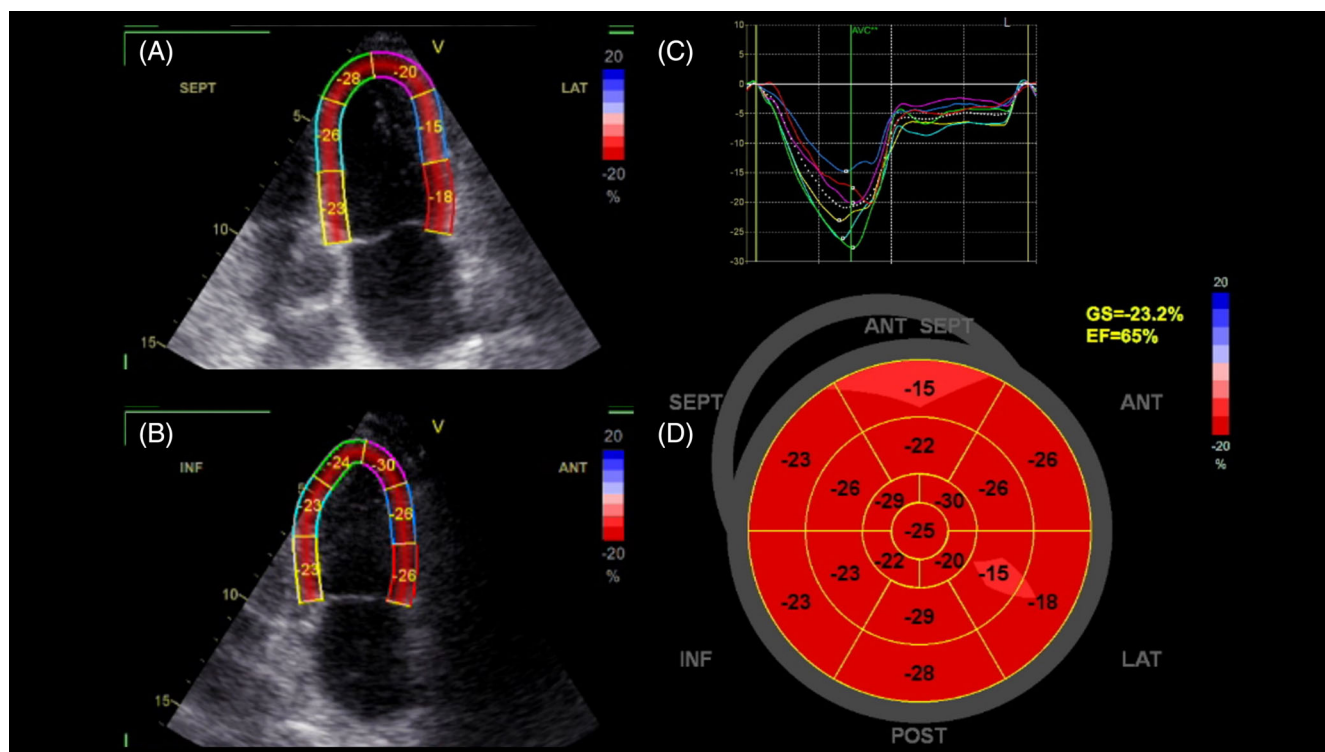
An example of speckle-tracking echocardiography is represented as left ventricular global and segmental strain analysis. A, An echocardiographic four-chamber view: the left ventricular septal (SEPT) and lateral (LAT) wall segments are drawn by the dedicated software (see the text); B, An echocardiographic two-chamber view with left ventricular with inferior (INF) and anterior (ANT) wall segments; C, The deformability curves that enable calculating the global longitudinal strain (GS); D, Bullseye segmental strain analysis of the left ventricle. EF, Ejection Fraction; POST, Posterior wall segments.
